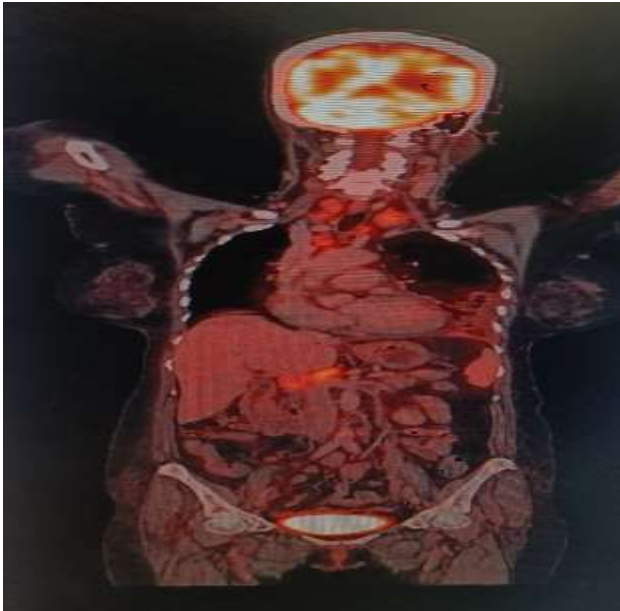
Whole body PET CT showing FDG avid bilateral supraclavicular, mediastinal and para-aortic lymphadenopathy.
